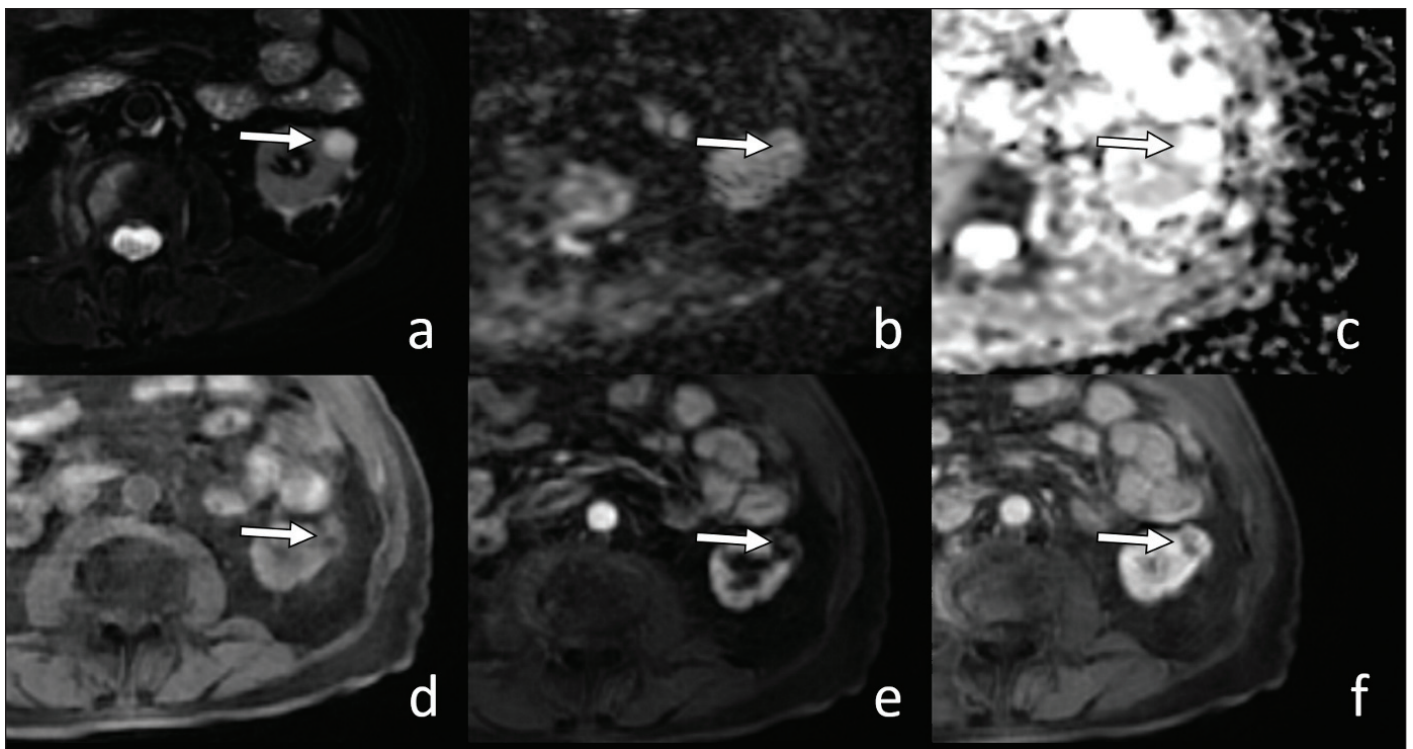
A small cystic renal cell carcinoma on the left kidney. *(a)* The lesion had a high signal on fat-suppressed T2-weighted image; *(b)* isointense signal on diffusion-weighted imaging; and *(c)* hyperintense signal on apparent diffusion coefficient were observed; *(d, e, f)* significant contrast enhancement of the solid component of the cyst was observed. Findings were compatible with Bosniak category 4.
